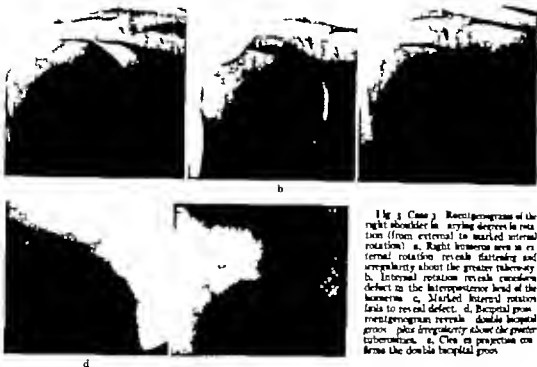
Case 3. Roentgenograms of the right shoulder in varying degrees of rotation (from external to marked internal rotation). a, Right humerus seen in external rotation reveals flattening and irregularity about the greater tuberosity. b, Internal rotation reveals cuneiform defect in the lateroposterior head of the humerus. c, Marked internal rotation leads to reveal defect. d, Biapical promontogram reveals double biapical grooves plus irregularity about the greater tuberosities. A clear projection confirms the double biapical grooves.
